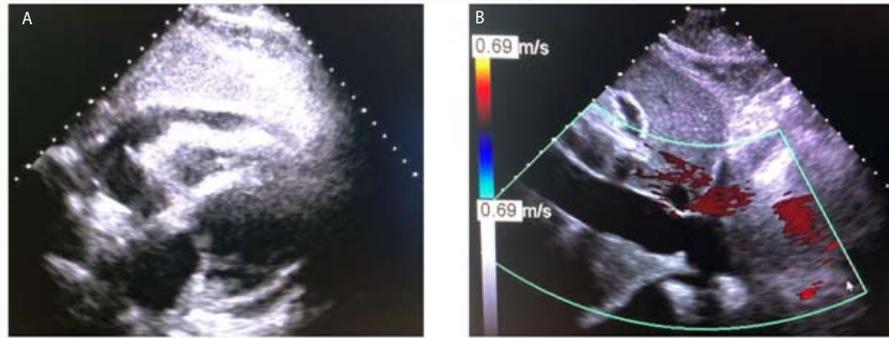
Large pericardial effusion, IVC 3 cm and diastolic RV collapse on subcostal images, confirming CT (A and B).
